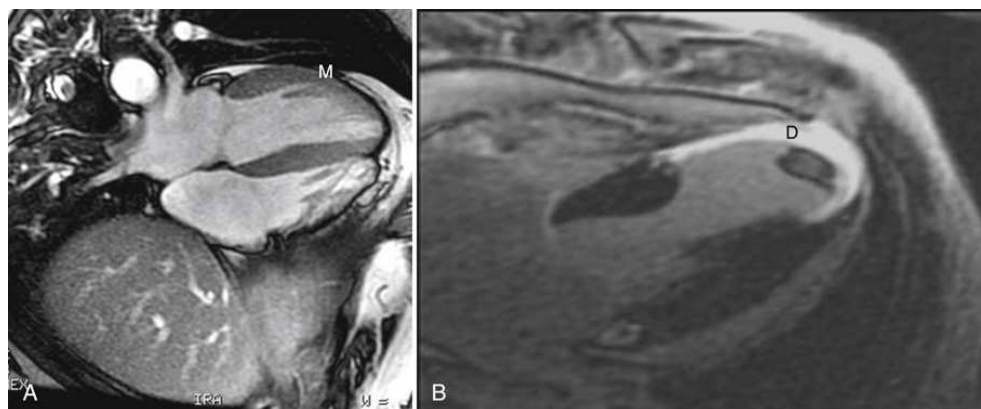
Cardiac MRI: four-chamber view from two different patients. (A) T2-weighted image showing normal myocardium in the wall of the left ventricle (*M*) before the administration of contrast medium. (B) Delayed-enhancement image (inversion recovery) showing bright signal in the wall of the left ventricle, representing infarcted or dead myocardium (*D*).
